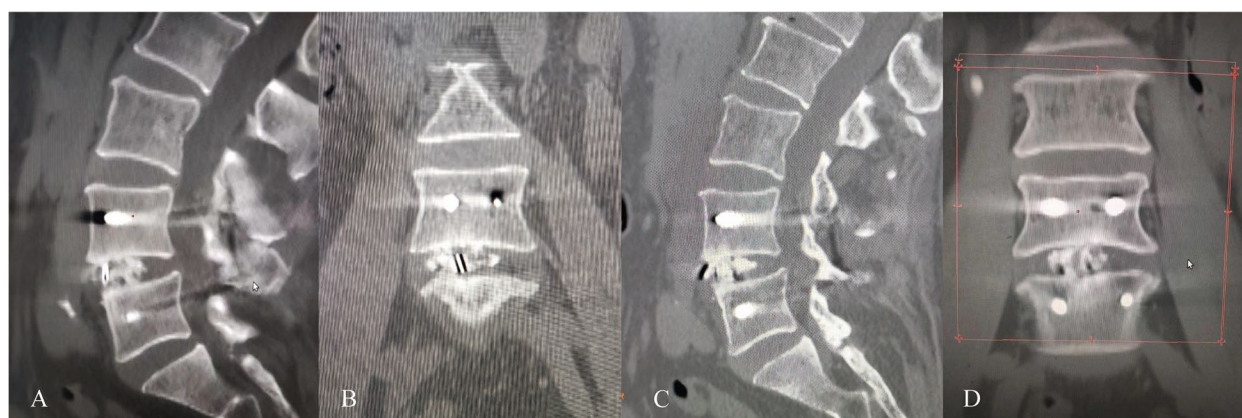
A, B At six months postoperatively, the CT scans in the sagittal and coronal planes showed an intact graft with incomplete remodeling, classified as a Grade II fusion; (C, D) at one year postoperatively, the CT scans in the sagittal and coronal planes demonstrated reconstruction of the trabeculae between the upper and lower endplates, classified as a Grade I fusion
